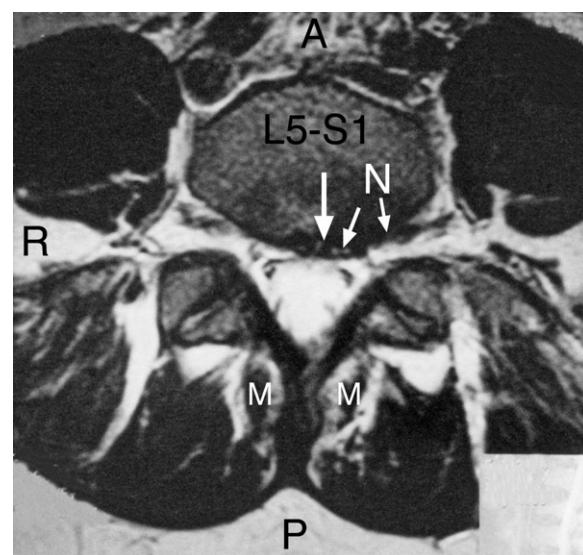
Lumbar spine MRI axial T2-weighted image through the L5-S1 disc level. Note the proximity between the L5-S1 central to left sided disc bulge (large white arrow) with a disc tear (small white arrow) to the nerve root (N) in the adjacent nerve root canal. In addition, there is early atrophy (degenerative change) of the multifidus muscles (M).
